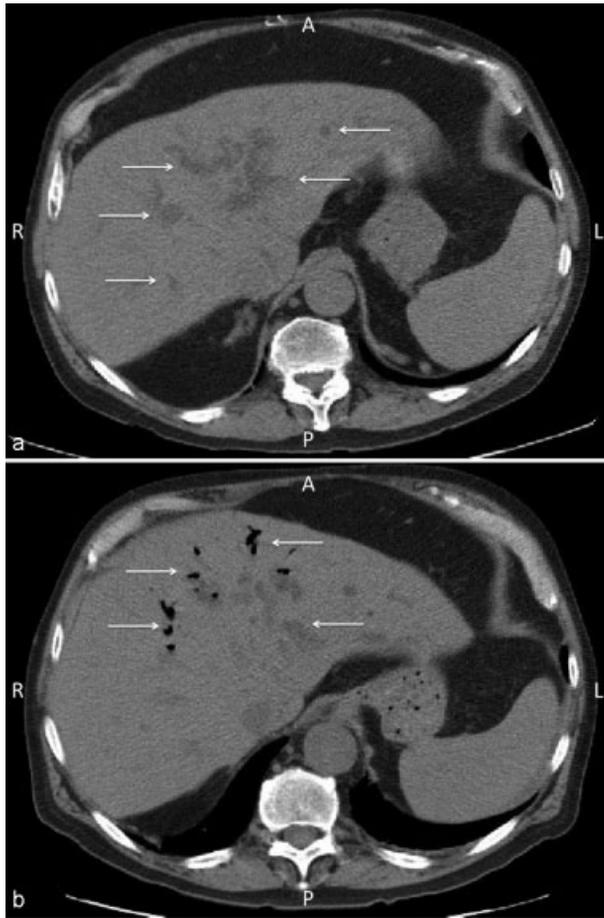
(a) Axial unenhanced CT scan of the liver in a patient who is s/p liver transplant with fever and sepsis. White arrows point to intrahepatic biliary ductal dilatation. (b) Axial unenhanced CT scan of the liver in a patient who is status post liver transplant with fever and sepsis taken 12 hours after scan obtained in (a). White arrows indicated new pneumobilia within dilated intrahepatic bile ducts, consistent with ascending cholangitis. CT, computed tomography.
